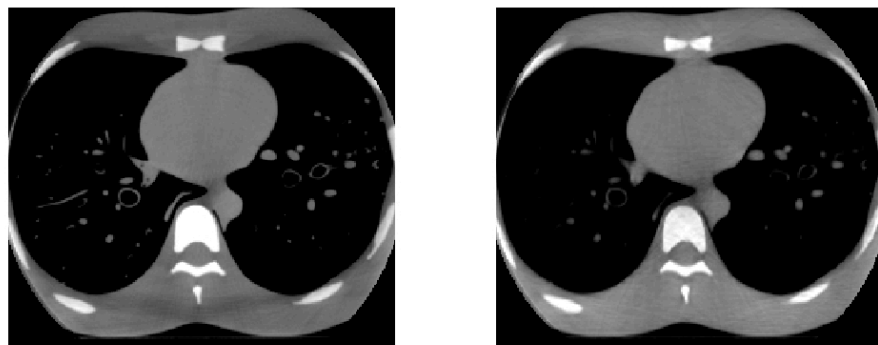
Reconstructed images* of the kV-CBCT (left) and the kV-MV-STR (right)
